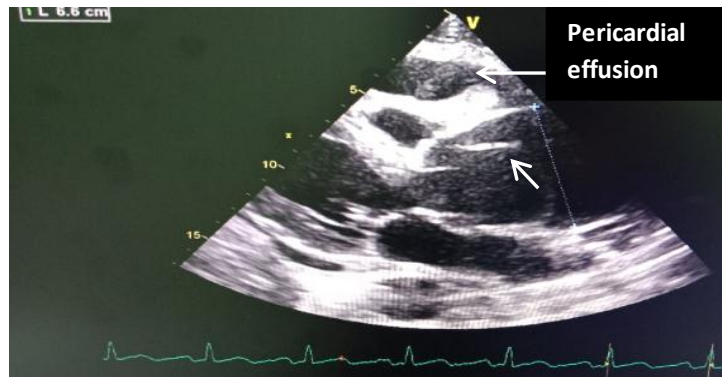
Transthoracic echocardiography showing the dissection flap in the Valsalva sinus (marked by arrow), pericardial effusion and the aortic aneurysm.
